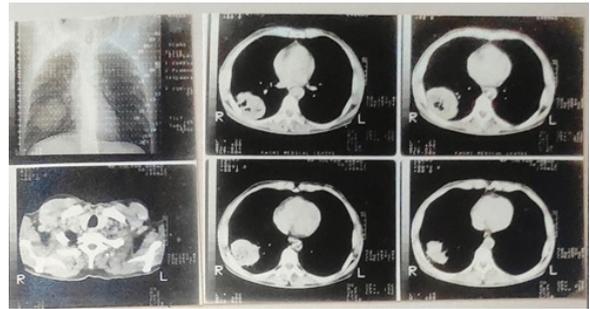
CT Scan of thorax reveals central necrosis in lesion
